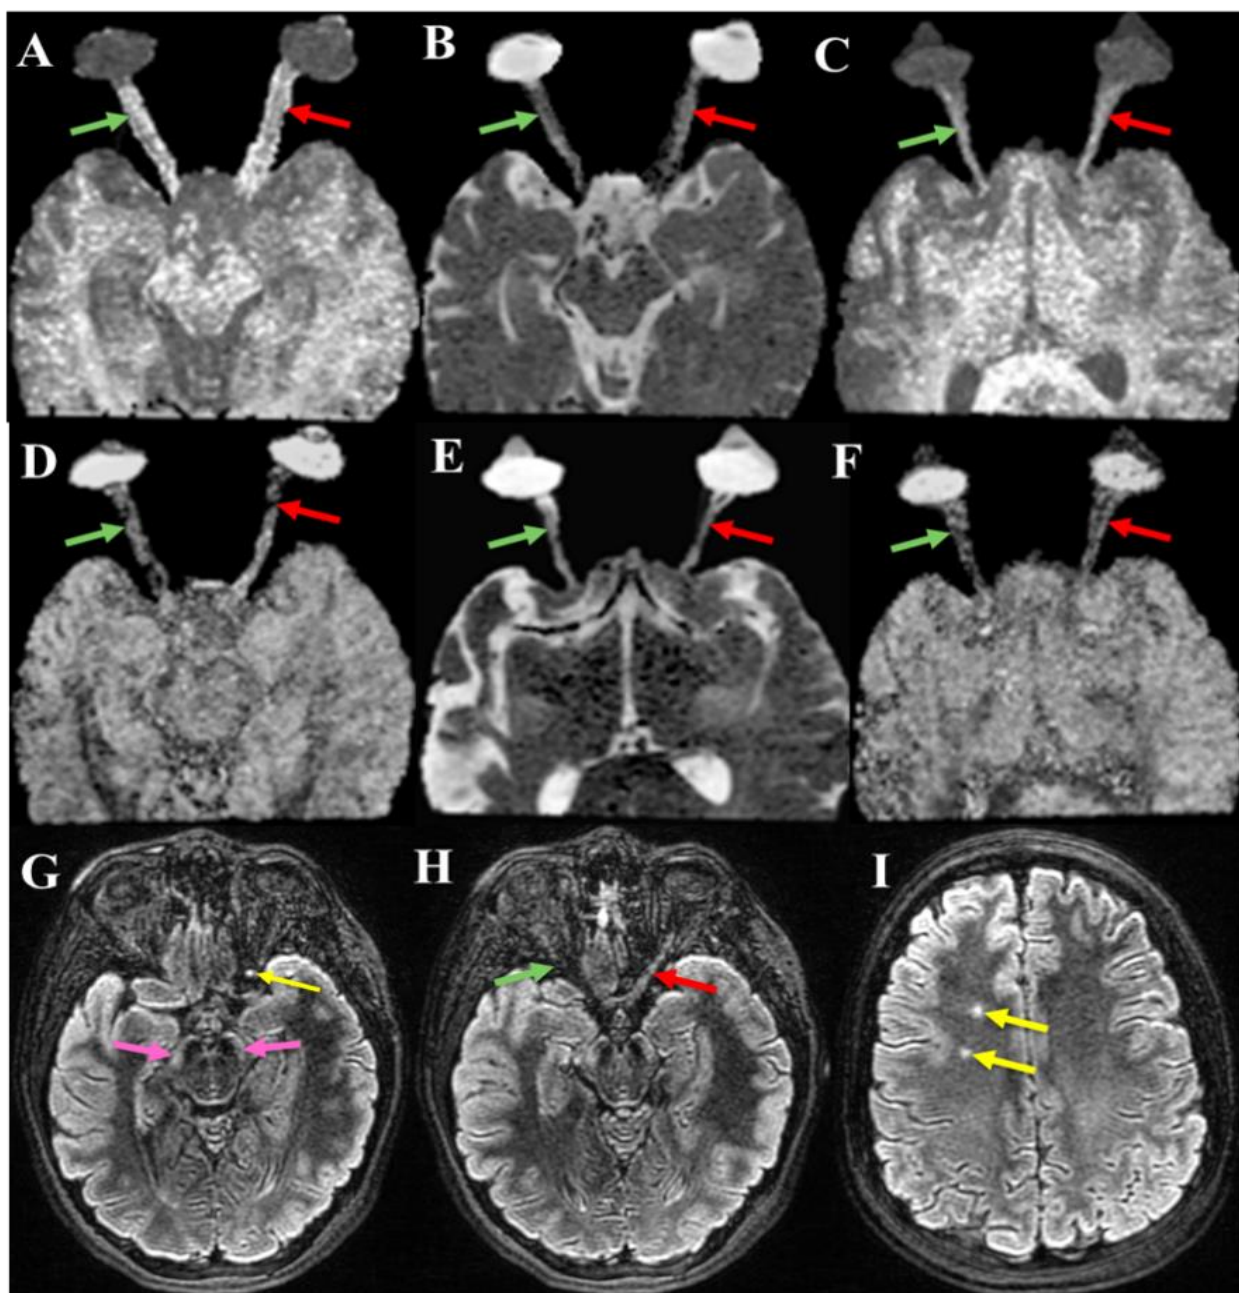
Changes in ON patient MRI. Example DWI images of (A) FA, (B) MD, and (C) ODI maps at baseline showing decreased FA, increased MD, and increased ODI in affected optic nerve (red arrowed) compared to contralateral optic nerve (green arrowed) indicating tissue injury. (D) FA, (E) MD, and (F) ODI maps of the same patient at 12 months MRI show similar signal intensity
